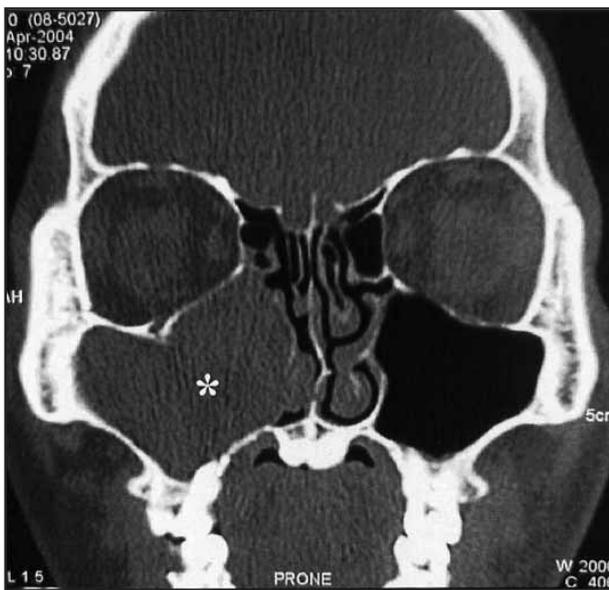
Coronal CT demonstrating soft-tissue density consistent with IP in the right maxillary sinus (*).
